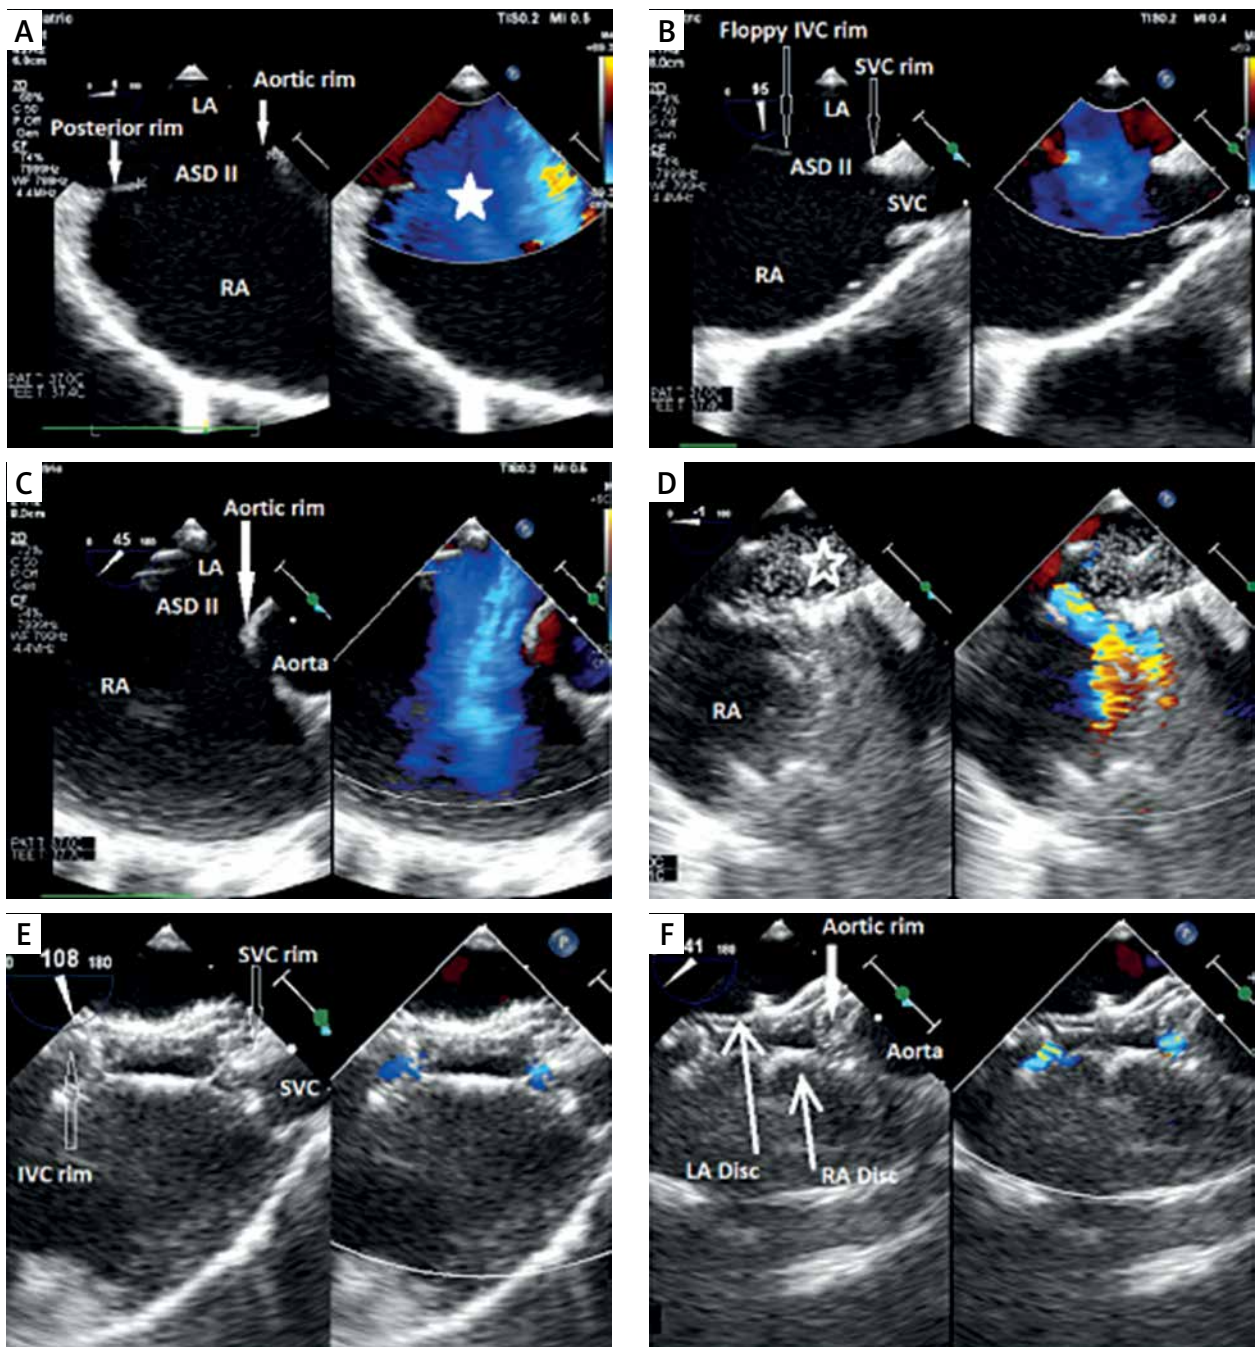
Transoesophageal images of device closure of a large secundum atrial septal defect with deficient superior vena cava. A – Four-chamber view (zoom); on the left side: secundum atrial septal defect in the middle part of the septum, dilated right atrium. Good visualization of the present posterior rim and deficient aortic rim; on the right side: TEE with colour Doppler showing a very large atrial septal defect with left-to-right shunt (white star). B – Bicaval view presenting a short superior vena cava rim and thin and floppy inferior vena cava rim. C – Short-axis view focused on the aortic valve showing lack of the aortic rim. D – Sizing balloon catheter inflated across the defect (empty white star) during simultaneous device deployment from the right upper pulmonary vein. E – Final result after release of the device; bicaval view with colour Doppler compare TEE showing typical device conformation with small residual leaks and unobstructed flow from the superior vena cava. F – Final result after release of the device: short-axis view with colour Doppler compare presenting the occluder well positioned on the aorta with small residual flow
